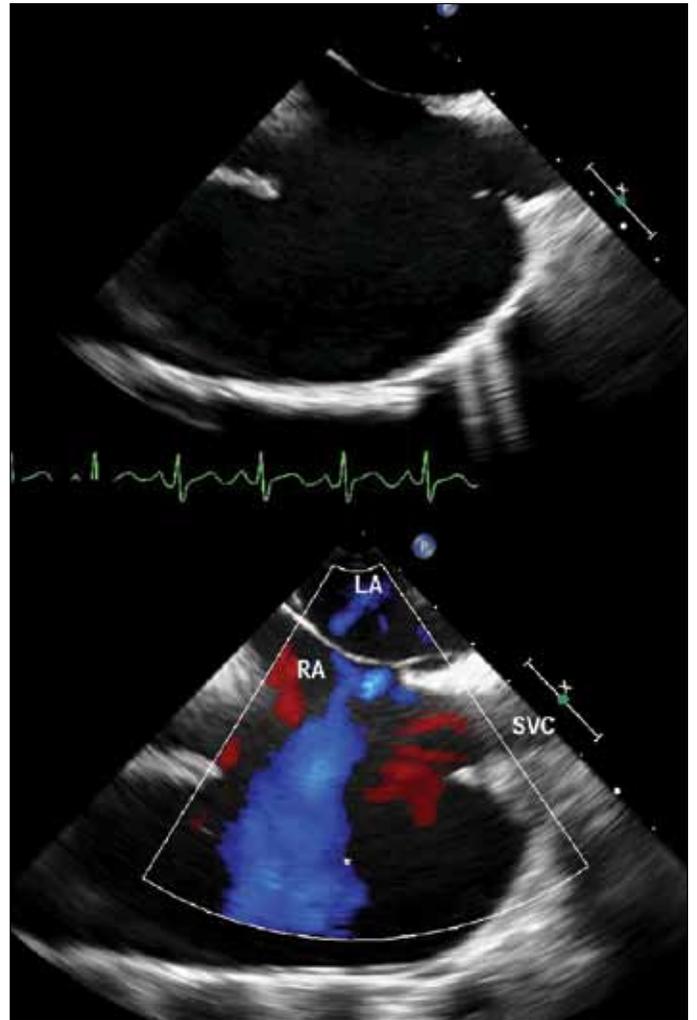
Transesophageal echocardiography in the 94° view revealed an 85 x 45-mm right atrial appendage aneurysm
